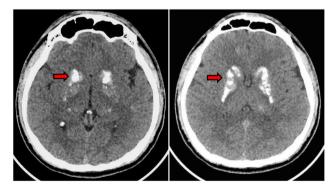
Cranial computed tomography (CT) scan of the patient. This image displays symmetrical high-density shadows in the bilateral basal ganglia, which could be indicative of calcifications
